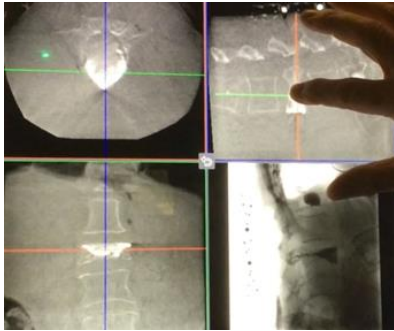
intraoperative cone beam computed tomography (CBCT) control of cement filling
